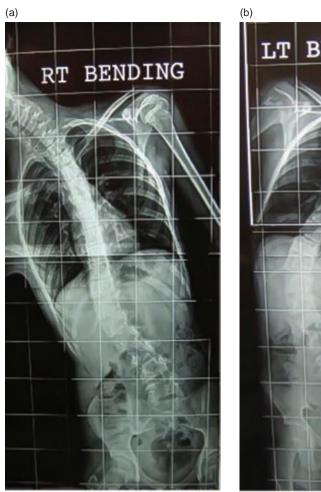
(a, b) Side-bending spine x-rays
